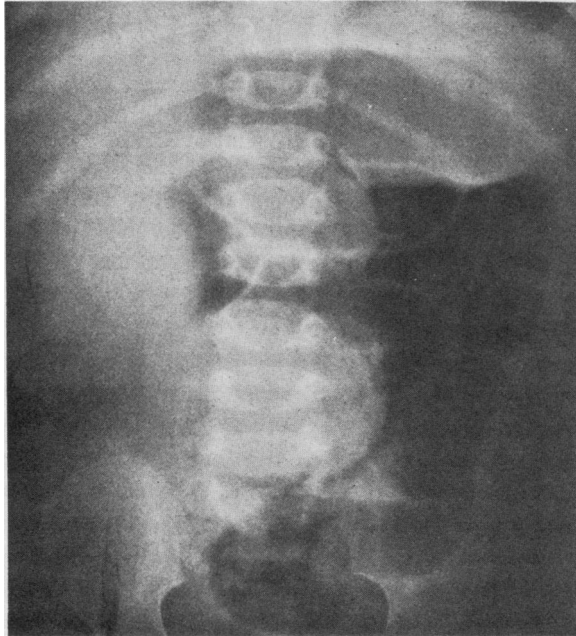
Roentgenogram indicates a mass on the right side of the abdomen.
